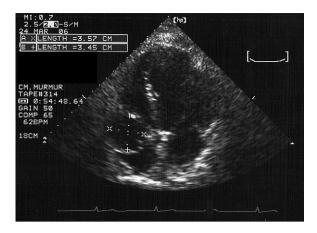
Echocardiography apical four-chamber view showing a spherical mass $(3.6\,\text{cm}\times3.5\,\text{cm})$ adjacent to the right atrium.
